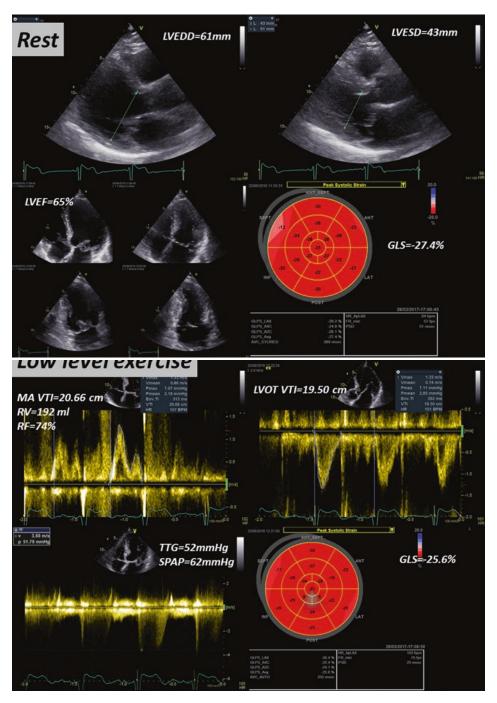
Panel a. Asymptomatic patient with severe organic mitral regurgitation (MR) due to a prolapse of the posterior mitral valve leaflet. The left ventricular end-diastolic diameter (LVEDD) is enlarged, as well as the end-systolic diameter (LVESD = 43 mm), the left ventricular ejection fraction is preserved (LVEF = 65%), as well as the GLS = -27.4%. The PISA method and the Doppler volumetric method indicate severe MR. Panel b. During low level exercise, there is a rapid increase in pulmonary artery pressure (SPAP = 62 mmHg) and a decrease
